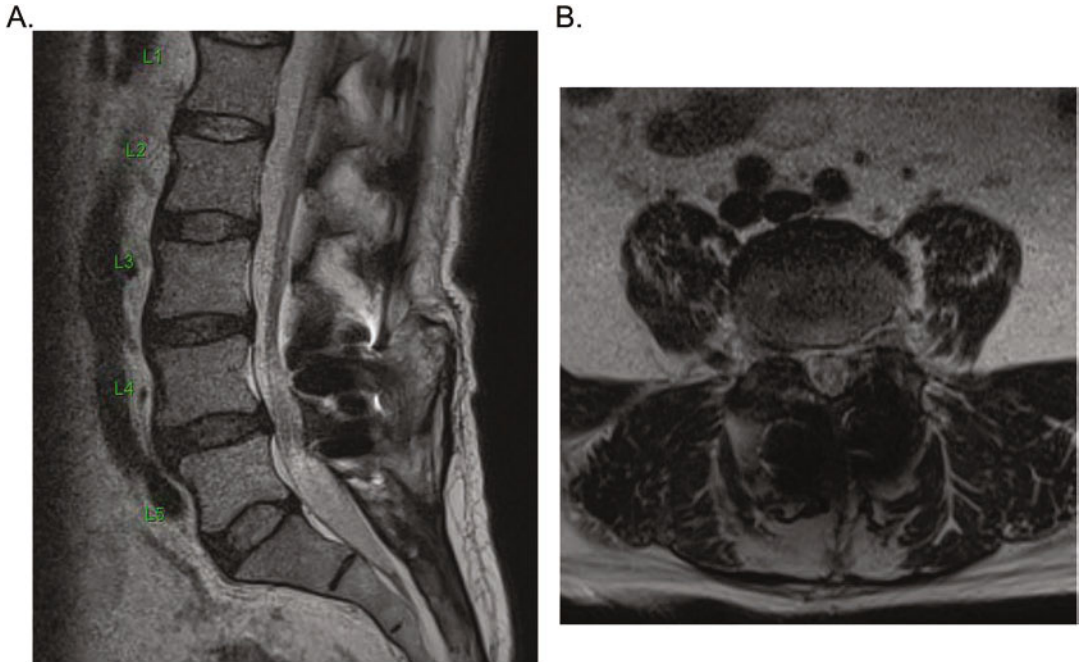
Pre-revision (a) sagittal and (b) axial MRI of the lumbar spine demonstrating recurrence of the L4–L5 degenerative spondylolisthesis
